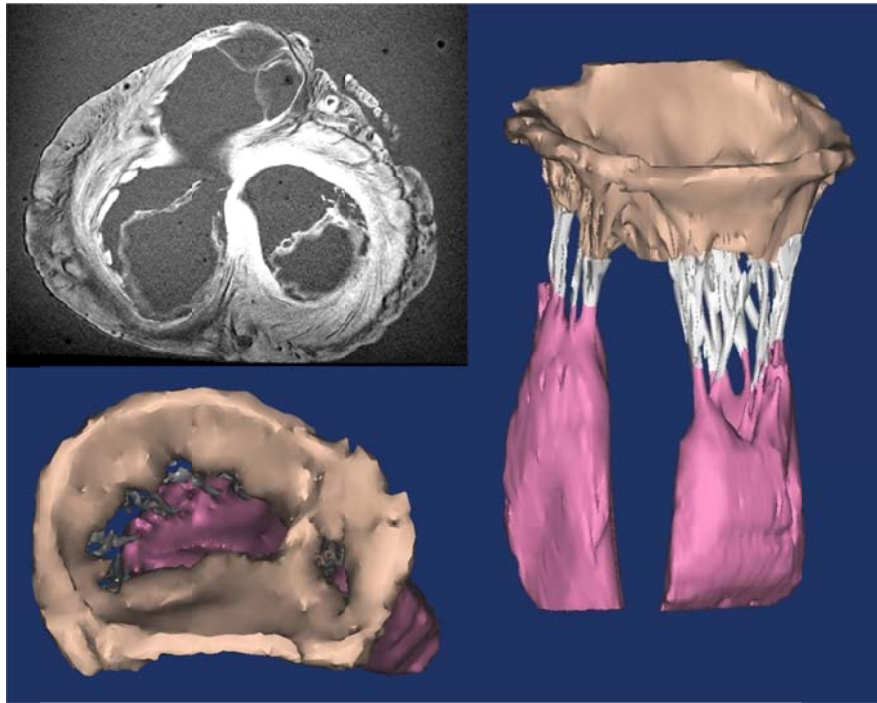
a) Short axis MR image taken at the level of the mitral valve. Mimics reconstruction of the DOMV viewed from above (b) and from the side (c).
